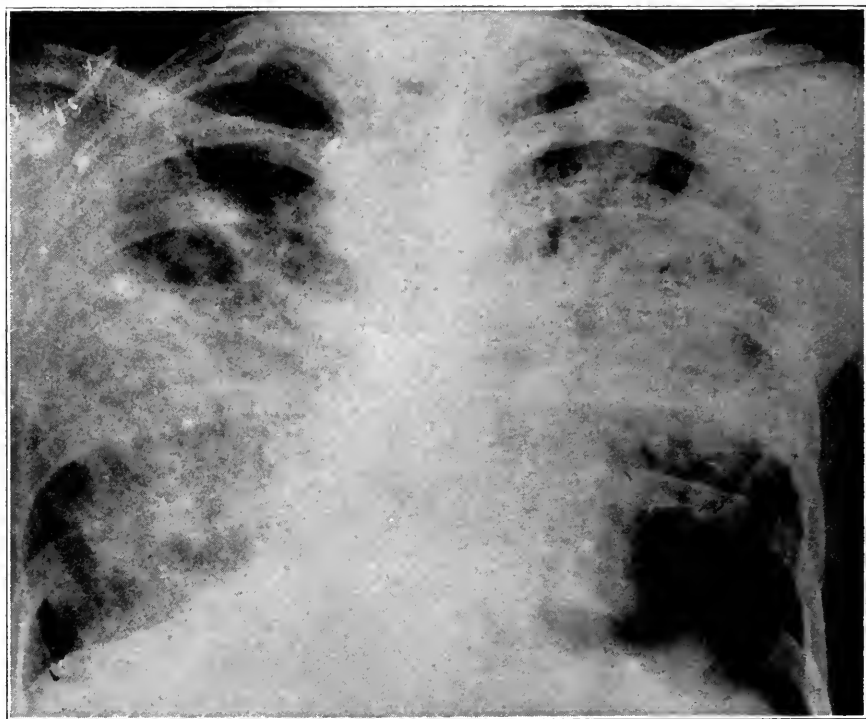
Case 811. Roentgenogram of the lungs in an advanced bilateral case showing the presence of a large typical cavity in the right lung and multiple cavitation throughout both lungs.
